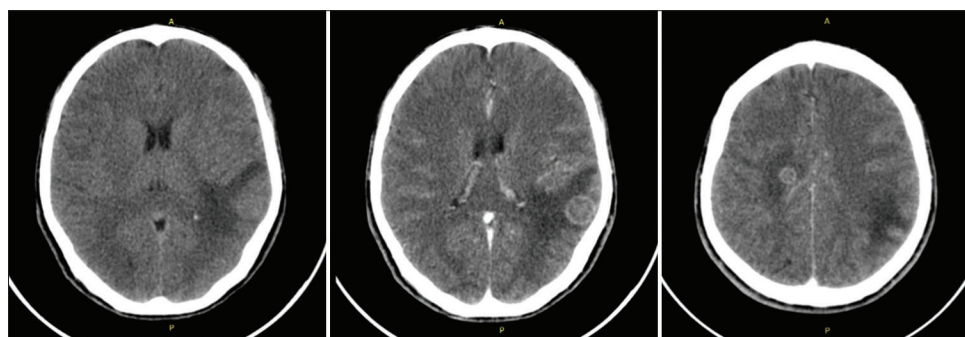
Computed tomography scans with contrast shows multiple ring enhancing lesions in the right frontal and left parietal lobes.
